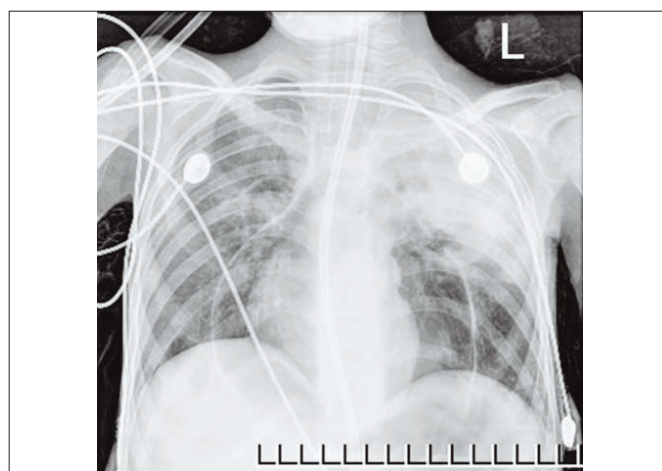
Chest radiography revealing massive pneumopericardium after intubation and positive pressure ventilation.
